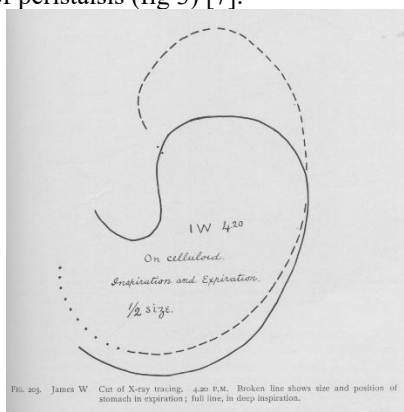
Cut of X-ray tracing of child examined by Williams and Cannon in September 1899. Stomach outlined by a mixture of milk, bread and bismuth. Broken line shows size and position of stomach on expiration, full line on inspiration, from Williams (1901).
